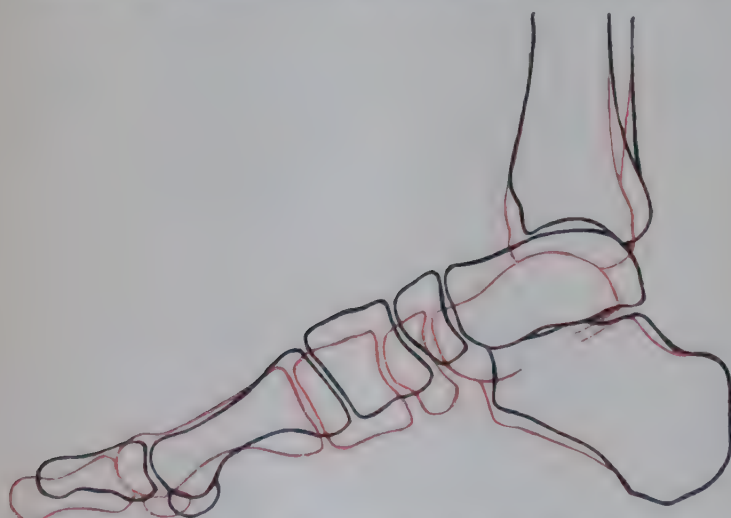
TRACING OF RADIOGRAPHS (Pl. XXXVI, p. 383, Figs. 2 and 3). Superimposed to show the position of the Longitudinal Arch of the Foot during Relaxation (red) and Contraction (black) of the muscles. (See also Fig. 472, Footprints 2 and 3.)
